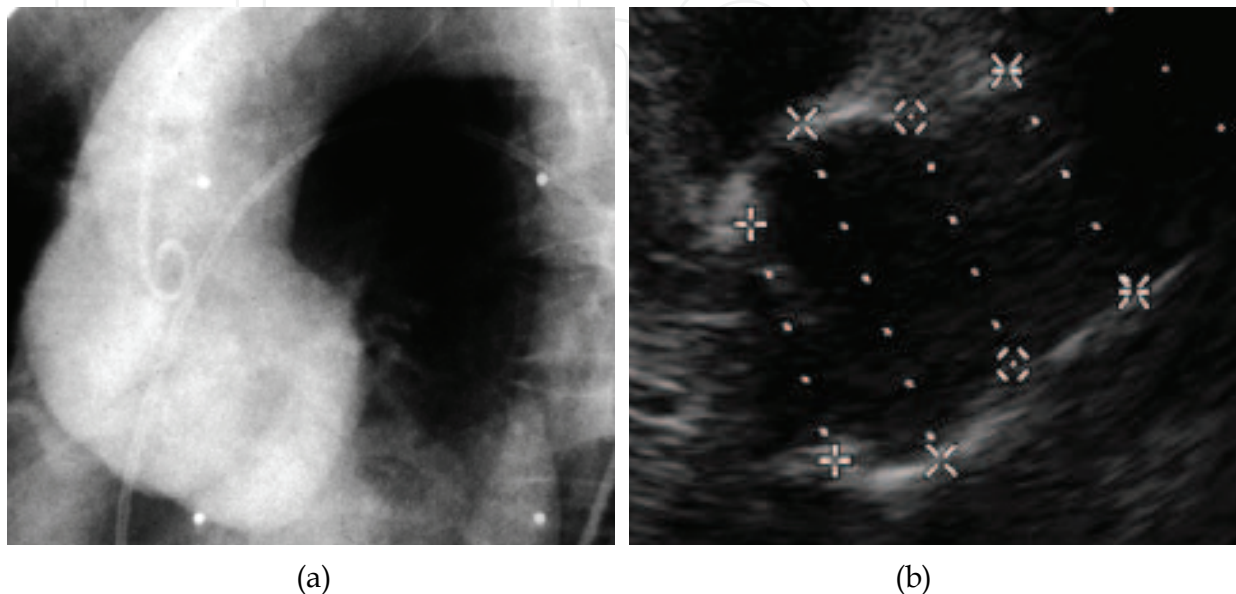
Images of aortic angiography (a) and transthoracic echocardiography (b) in BAV patient with a “root phenotype”
